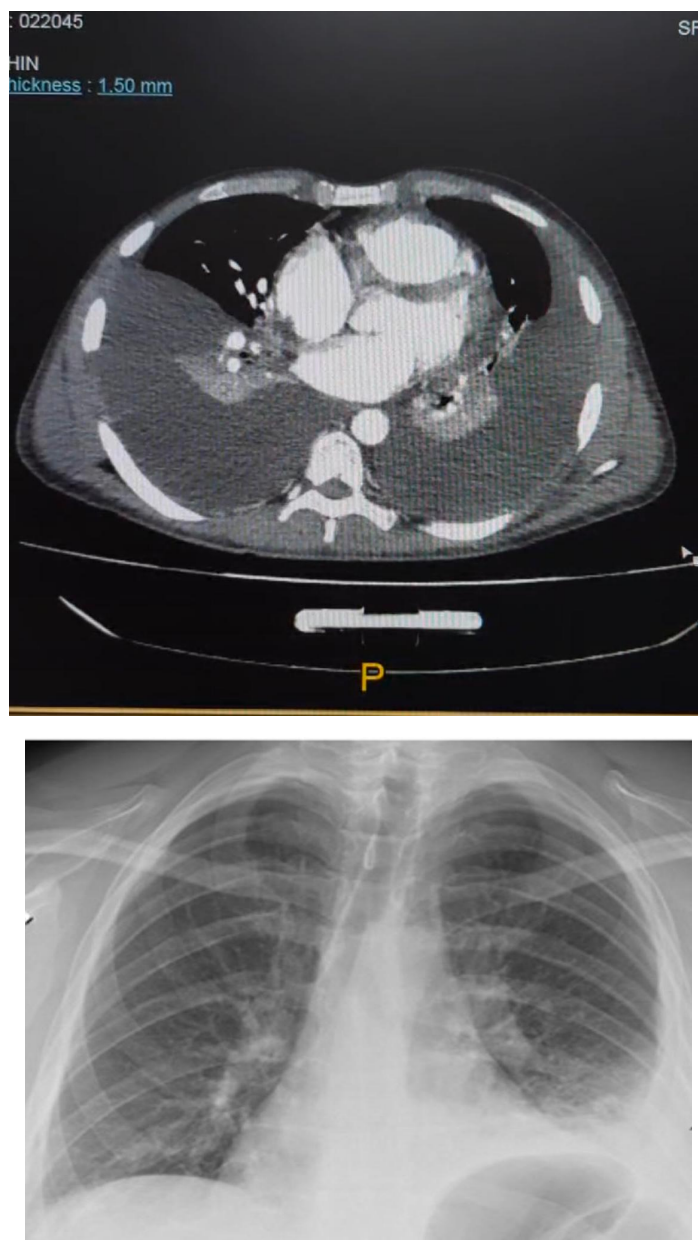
Follow-up posteroanterior chest radiograph obtained after permanent discontinuation of dasatinib and initiation of nilotinib, showing near-complete resolution of bilateral pleural effusions, re-expansion of the lung bases, and restoration of costophrenic angles, with minimal residual left-sided pleural fluid.
